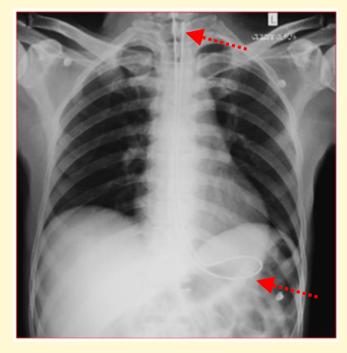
Chest radiograph showing coiling of NG tube in stomach and tip is seen in the neck.
